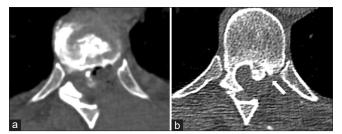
(a) 2014 postoperative computed tomography (CT) scan in T8–T9 axial plane and (b) 2022 CT scan in T8–T9 plane. The comparison between the 2014 postoperative CT scan and the 2022 control CT scan at the same level confirmed the presence of the residual calcific disc at the T8–T9 level, with a new calcified herniated fragment on the left (white arrow in b).
